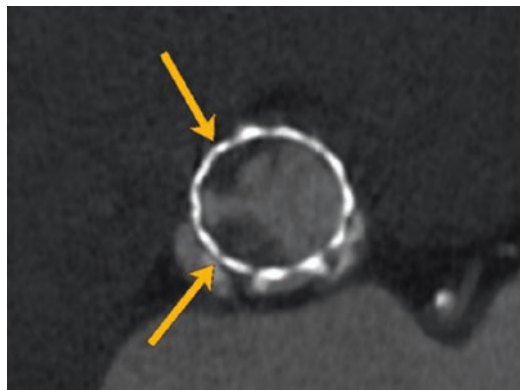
Bioprosthetic aortic valve with thrombus (HALT) and restricted leaflet mobility on CT as shown by arrows
